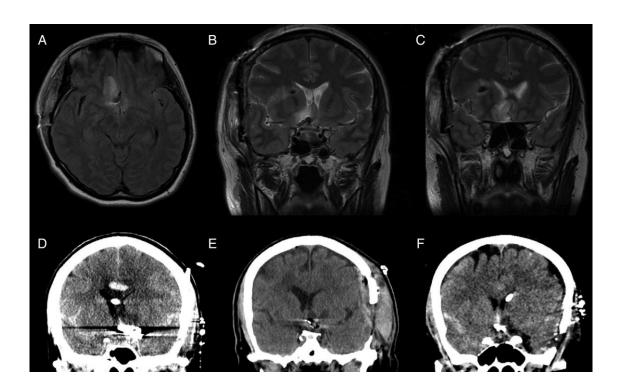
Axial FLAIR (A) and T2 coronal (B and C) images demonstrating ischemic injury to the right septal and subcallosal region. Note also the high signal in the contralateral left subcallosal region, although this is less marked. Coronal CT reconstructions (D–F) in three additional patients with a similar pattern of infarction.
